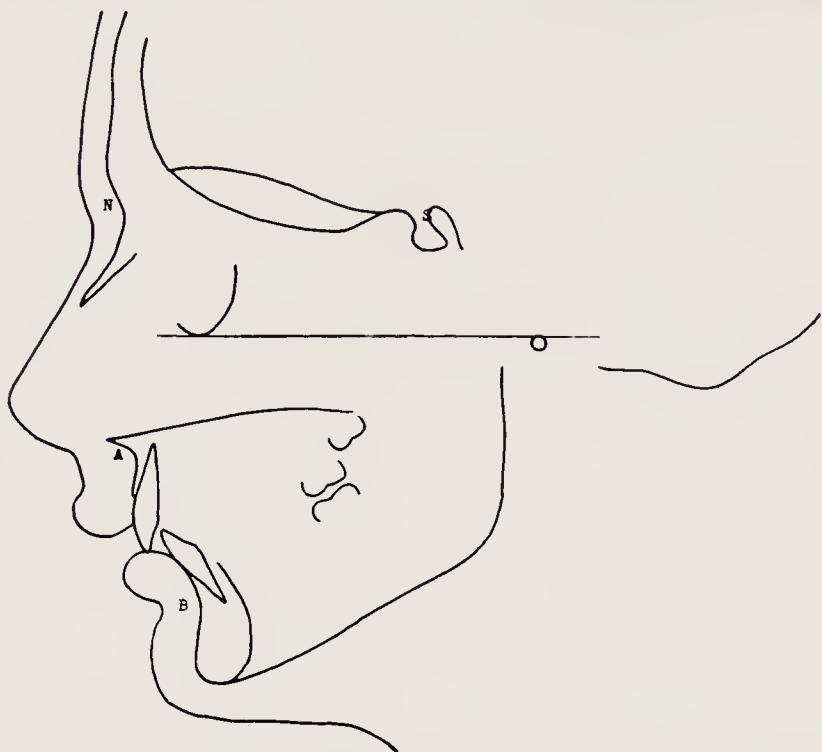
Tracing from lateral radiograph at rest.
